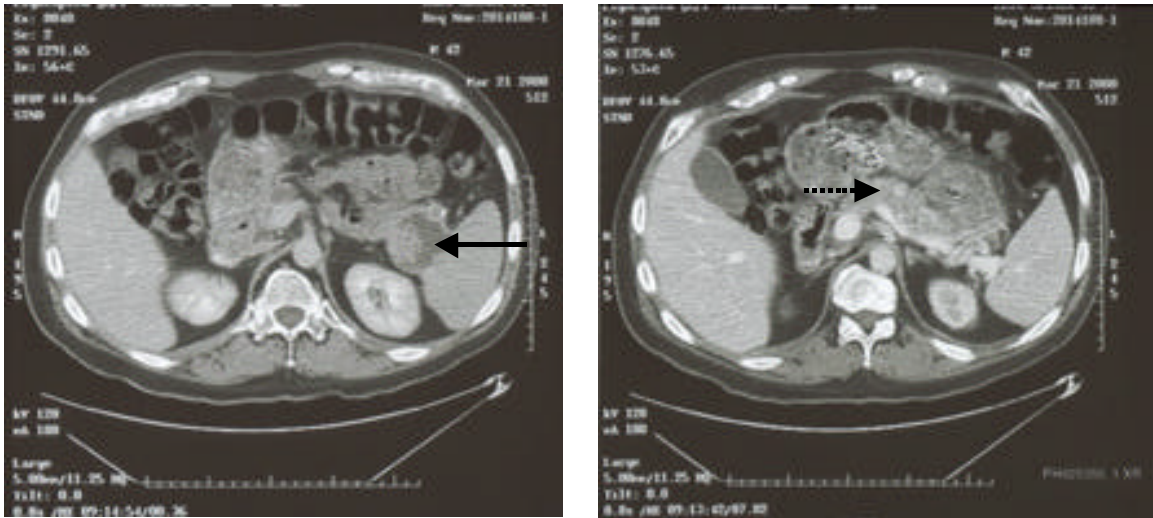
Computed tomographic scan of the abdomen demonstrating a large heterogenous mass in the tail of the pancreas (solid arrow) with evidence of other smaller tumors in the body of the pancreas (dotted arrow)
